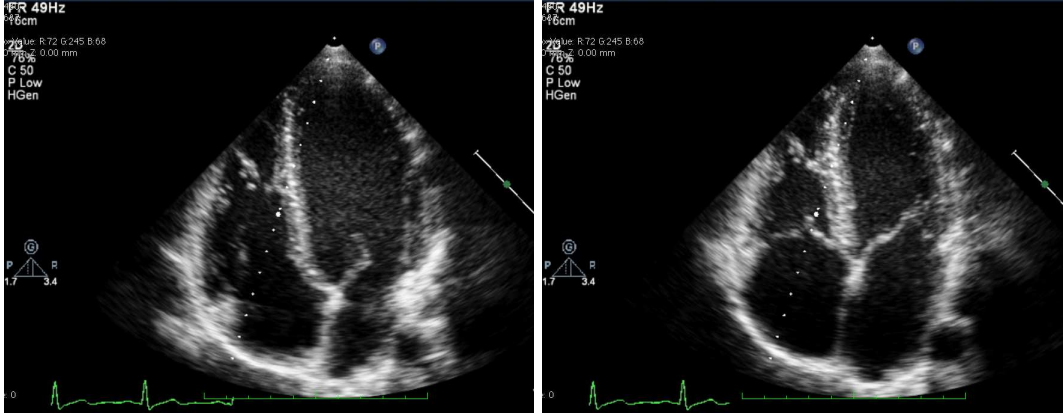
A 4-chamber projection using 2D echocardiography can give an approximate value of the LV ejection fraction (left: end-diastole, right: end-systole).
